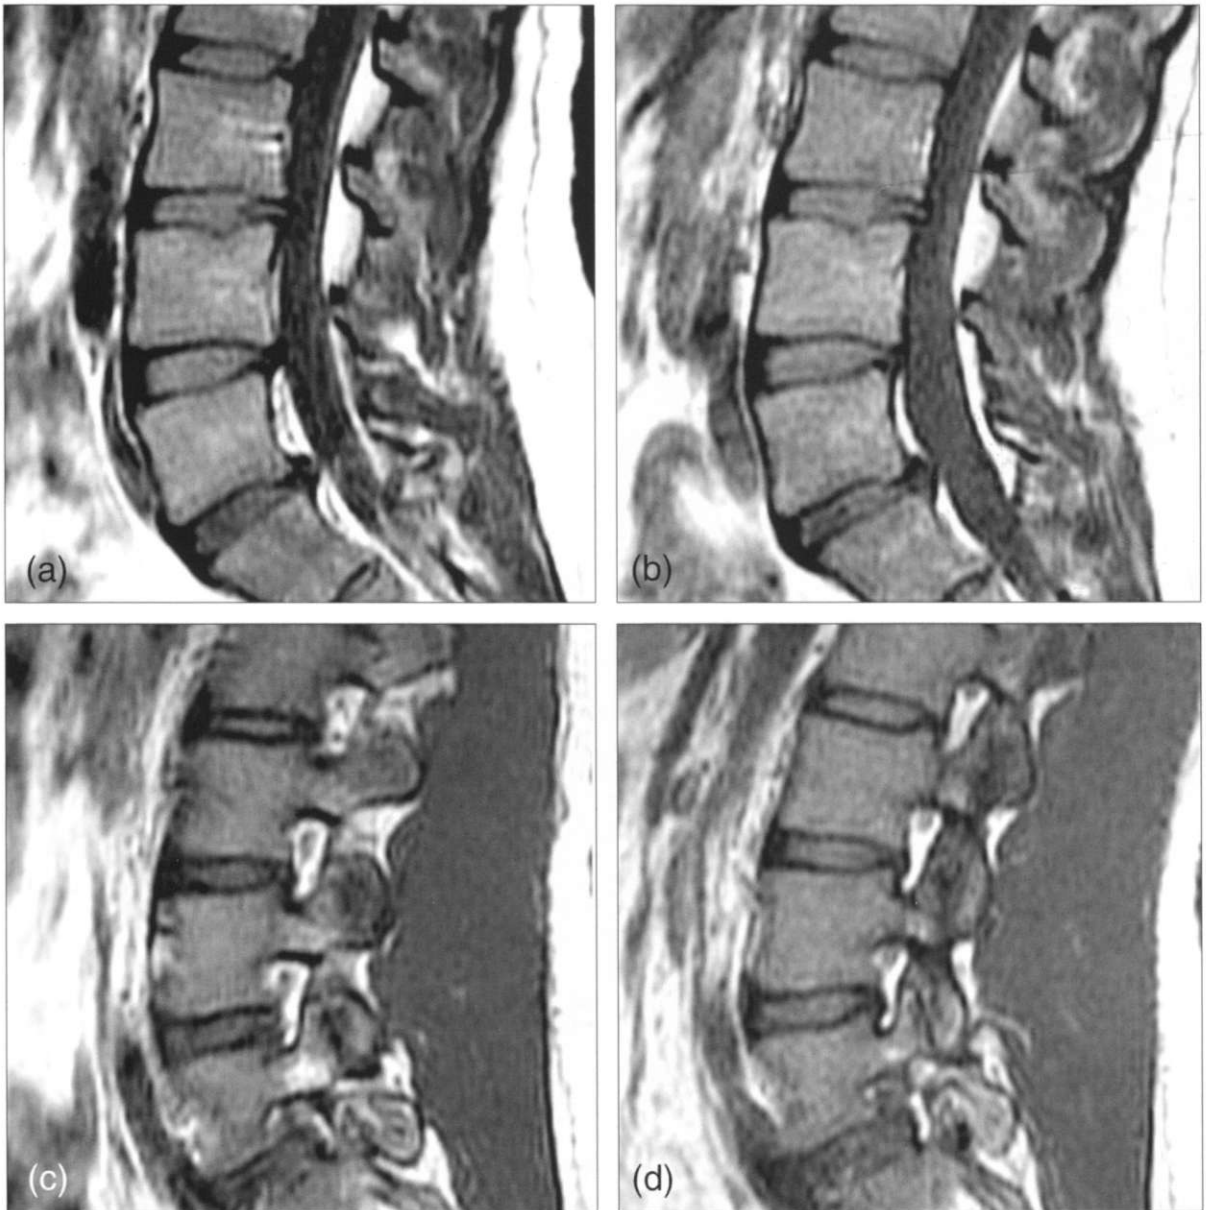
Effects of gravity on the intervertebral disc, thecal sac, and spinal neural foramina. (a) Recumbent midline sagittal T1-weighted fast-spin echo MRI (rMRI) shows a focal disc herniation at L5/S1 and mild narrowing of the superoinferior disc height at this level. (b) Upright-neutral midline sagittal T1-weighted fast-spin echo MRI (pMRI) shows minor further narrowing of the height of the L5/S1 intervertebral disc and further, minor posterior protrusion of the disc herniation at this level. Also note the generalized expansion of the thecal sac because of gravity-related hydrostatic CSF pressure increases and the consonant decrease in the dimensions of the anterior epidural space. (c) Recumbent midline sagittal T1-weighted fast-spin echo MRI (rMRI) on the patient's left side shows narrowing of the L5/S1 spinal neural foramen as a result of posterior disc protrusion, intervertebral disc space narrowing and paradiscal osteophyte formation. (d) Upright-neutral midline sagittal T1-weighted fast-spin echo MRI (pMRI) on the patient's left side reveals generalized narrowing of all of the spinal neural foramina, including the L5/S1 level, as compared to the recumbent examination.
